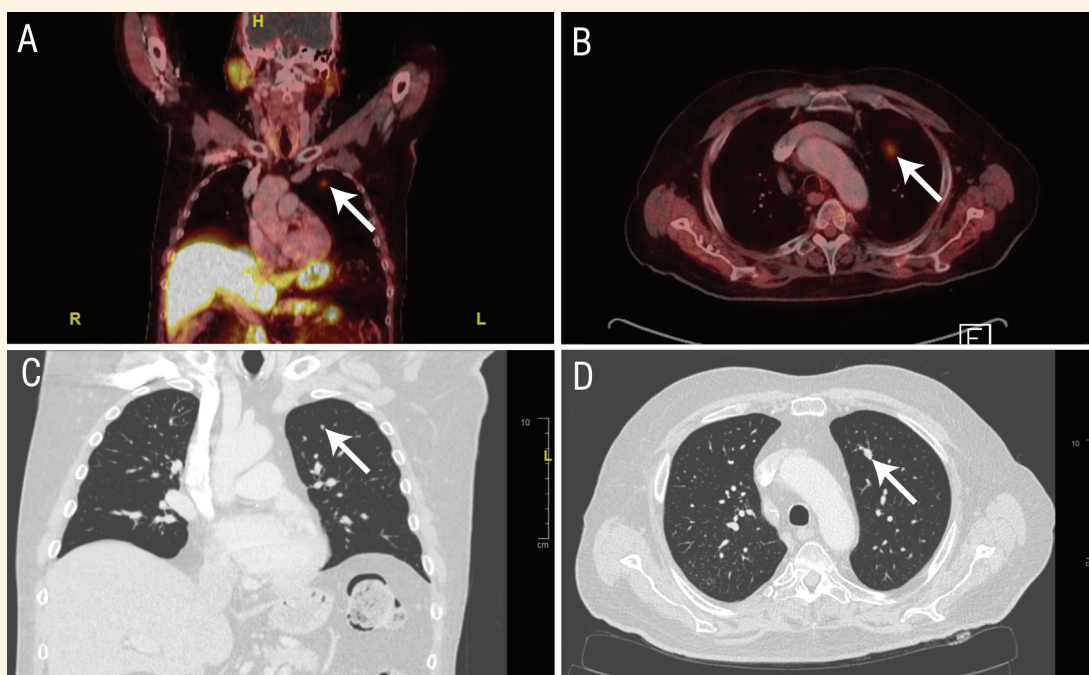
⁶⁸Ga-DOTATATE positron emission tomography/computed tomography (PET/CT) with contrast scans of a 64-year-old male patient with ectopic Cushing's syndrome showing the (A) coronal and (B) axial views of fused DOTATATE PET/CT and (C) coronal and (D) axial views of chest CT with an abnormal signal in the left upper lung nodule (arrows).
